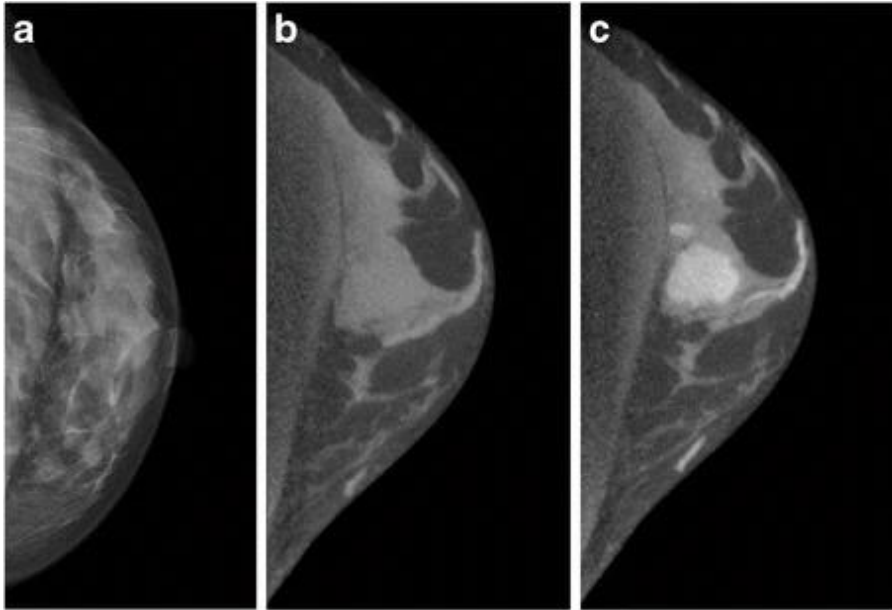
Comparison of mammography and breast CT on the example of an invasive ductal carcinoma.
